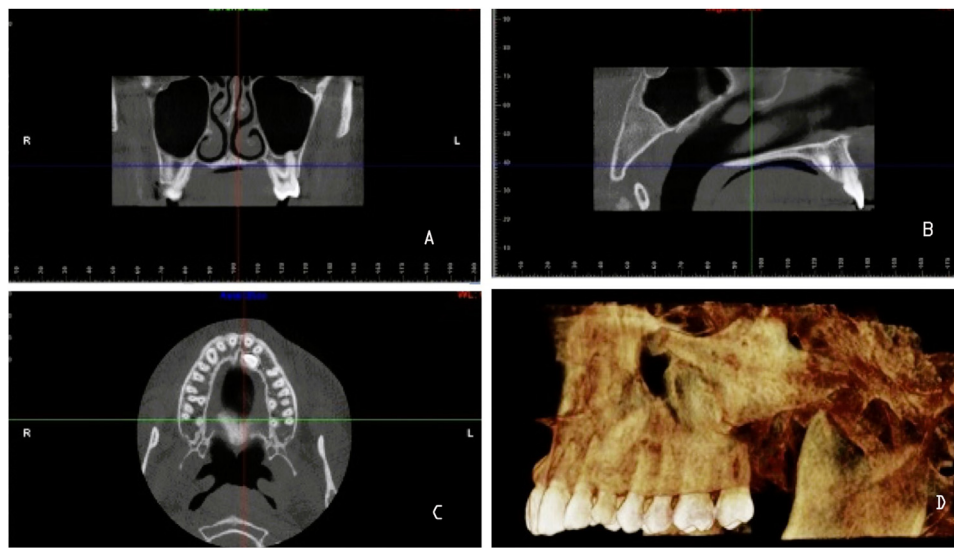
Location of the slices in the Carestream 3D Imaging software (Atlanta, Ga) for measuring the DB root area of the maxillary second left molar: A, Location of the coronal slice, with a complete view of the root being studied; B, Sagittal section, which enables locating the posterior region of the maxilla; C, The axial plane, which offers a view of the root canal of the root to be studied; D, Three-dimensional reconstruction of the CBCT.
